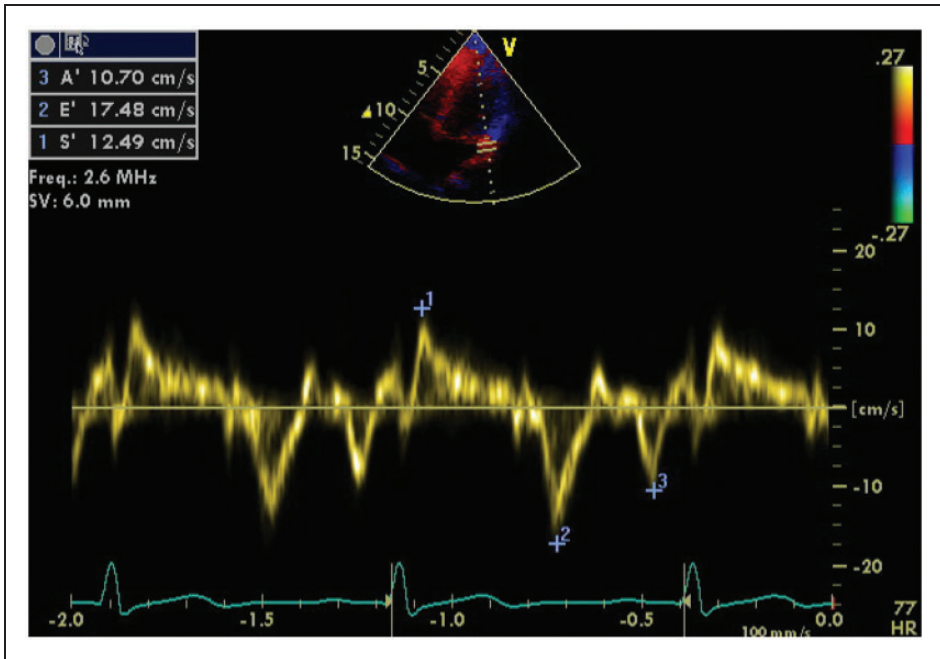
An example of transthoracic echocardiographic assessment using tissue Doppler imaging in the evaluation of effect-site concentration of propofol and cardiac systolic function in patients undergoing cardiovascular procedures. s' velocity, upward deflection during systole (systolic myocardial velocity); e' velocity, downward deflection corresponding to early diastolic phase (early diastolic myocardial relaxation velocity); a' velocity, downward deflection corresponding to late diastolic phase (late myocardial relaxation velocity with atrial contraction); Freq, frequency; SV, stroke volume; HR, heart rate. The colour version of this figure is available at: <http://imr.sagepub.com>
